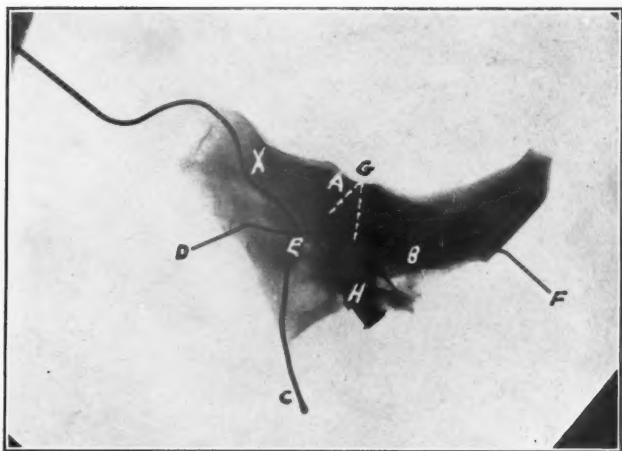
Roentgenogram of temporal bone taken from above with probes in place to show direction of opening into petrous apex. A, postero-superior border of petrosa. B, squamous plate. C, probe in carotid canal. D, E, probe in eustachian tube extended backward to F to show angle made with H, probe entering through surgical avenue of approach to the petrous apex. G, cochlea and vestibule injected with lipiodol. X, petrous apex.
